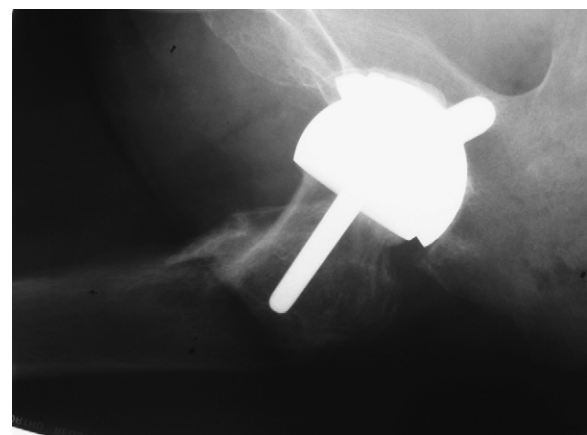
Patient 1 radiograph lateral right hip (United).
